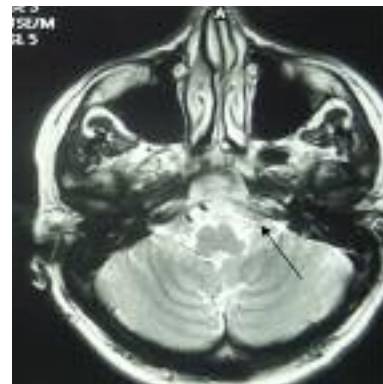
Preoperative sagittal T2 weighted MRI showing compression of cranial nerve IX (black arrow).
